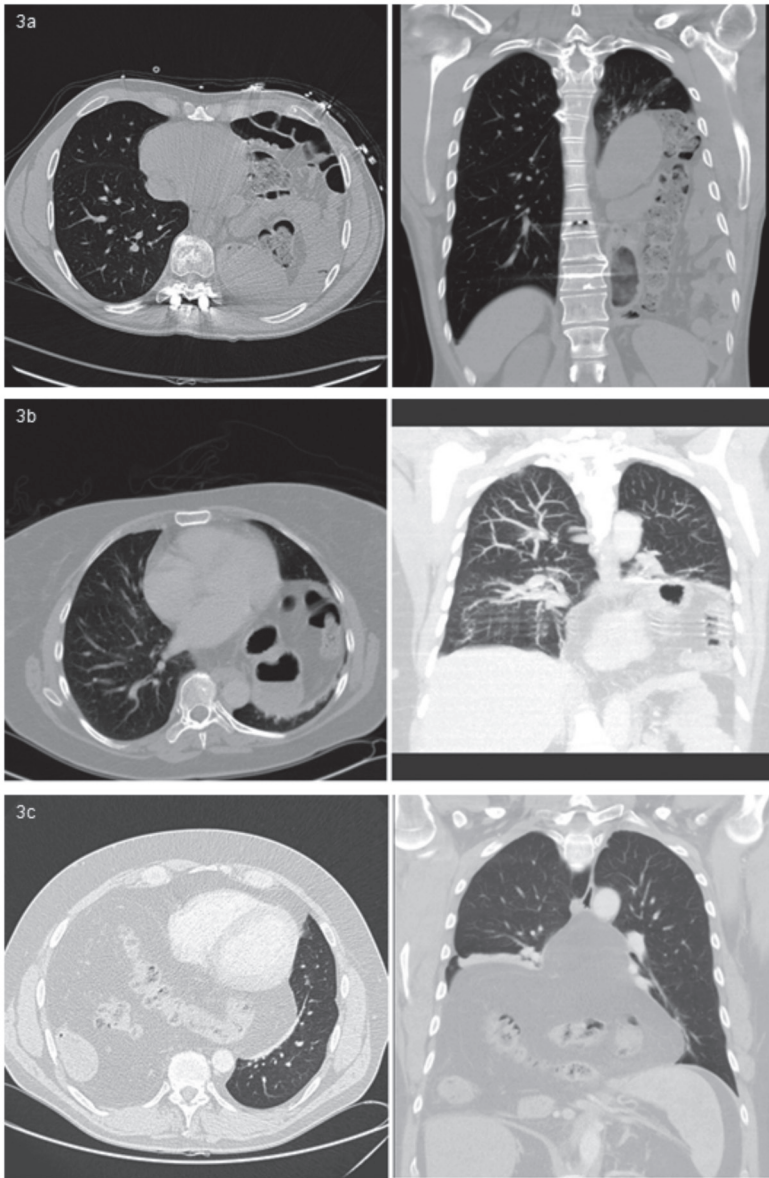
(a) Preoperative cross sectional and coronal CT-scan of the chest of patient 1 demonstrating intrathoracic stomach, small intestine and colon. (b, c) Pre-operative cross sectional and coronal CT-scan of the chest of patients 2 and 3, respectively demonstrating intrathoracic stomach, small intestine and colon.
